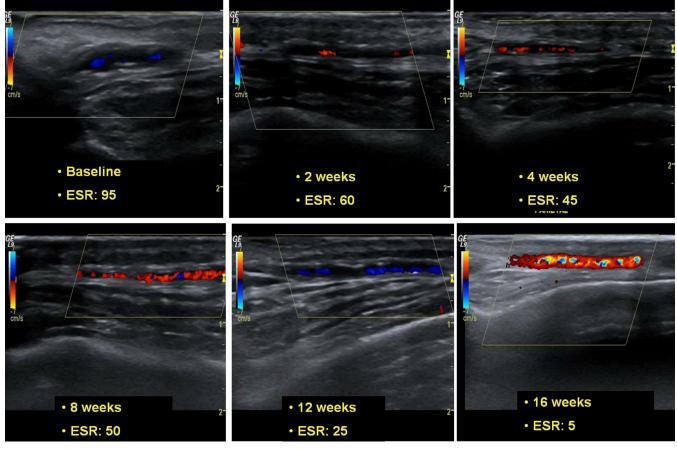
Colour Doppler ultrasound follow-up (dark halo evolution in a patient between baseline and disappearance at week 16).
